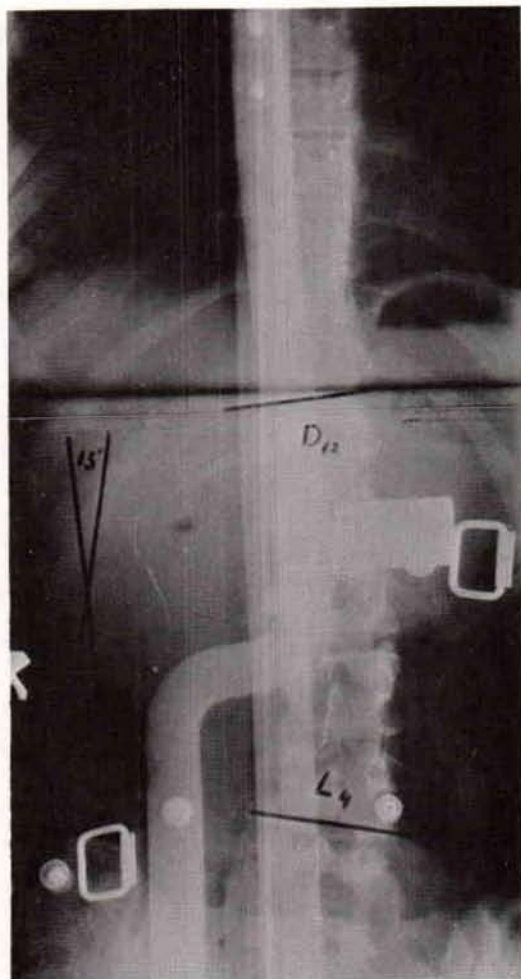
X-ray of the patient shown in Figure 3 wearing the brace. Correction of the curve to 13 deg. was achieved immediately.
